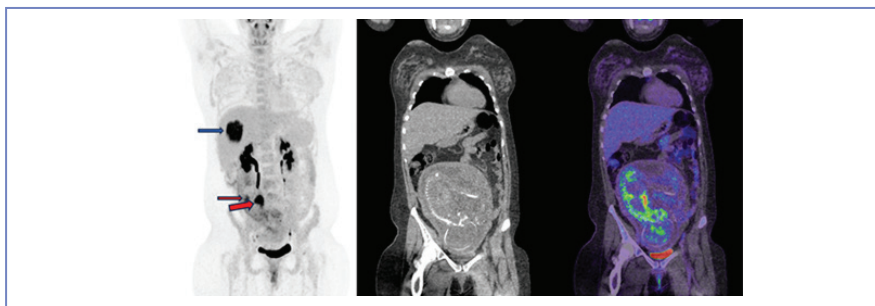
27-year-old female (63 kg), 25 weeks pregnant. Referred for assessment of new liver lesion on background of colorectal cancer. Patient received radiation counselling for potential foetal risk and written consent was obtained. 116 MBq [¹⁸F]FDG was administered, CT for attenuation correction was acquired using parameters 100 kVp and 20 mAs. Estimated foetal dose was calculated to be approximately 2 mGy. Due to reduced administered [¹⁸F]FDG activity, image acquisition time was increased by a factor of 2. Increased hydration and voiding were recommended. Blue arrow represents solitary segment VII liver lesion, SUV max 12.7. Thin red arrow represents foetal kidney and thick red arrow represents foetal heart. Images acquired using Siemens Biograph Vision 600 Edge digital PET/CT scanner.
